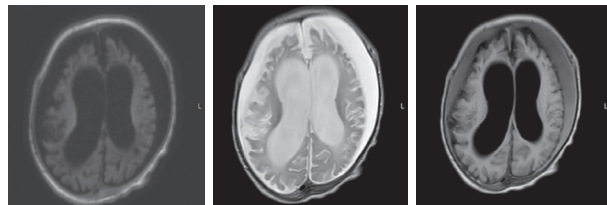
Magnetic resonance imaging of a patient at the age of 7 months. Axial sections, T1 VI, T2 VI, Flair. There is a bilateral cystic encephalomalacia of the large hemispheres of the brain, atrophic expansion of the external and internal liquor spaces – a moderate increase in the severity of changes. Bilateral chronic subdural hematomas (hygromas) – a moderate increase in fluid volume
